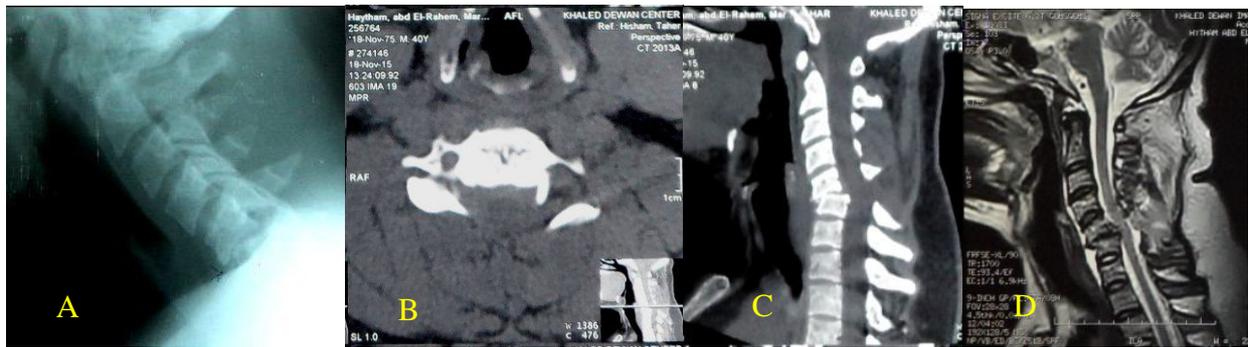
Male patient with 17 years old, with history of road traffic accident presented by upper limbs diparesis (Grade 3). (A) Pre-operative plain X-ray cervical spine, (B) axial CT scan and (C) sagittal CT scan and (D) sagittal MRI views, with C5-6 anterolithesis, with bilateral locked facets.
